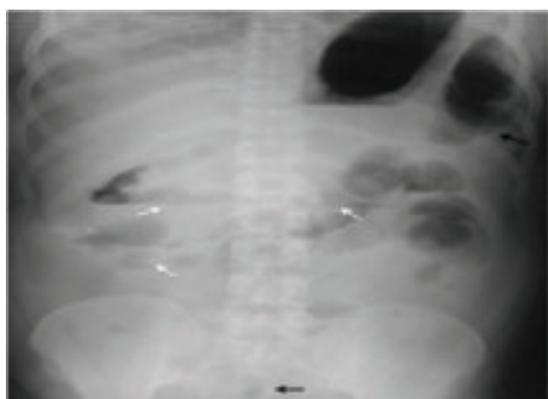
Plain radiograph of the abdomen (erect position) reveals few small air-fluid levels (white arrows) predominantly in the mid abdomen. Note that there is presence of air in the large bowel (black arrows).
